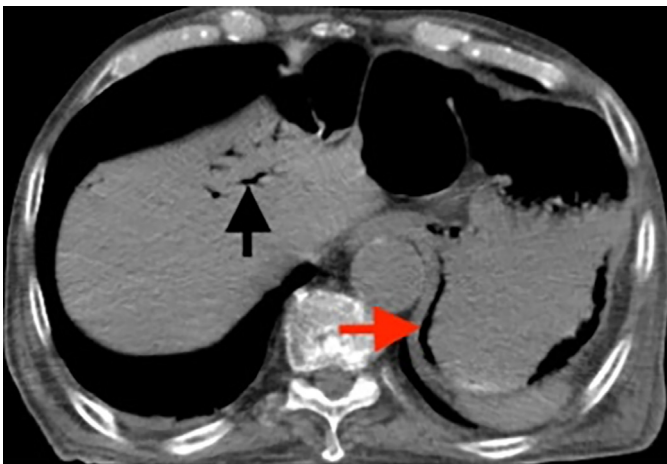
CT image of emphysematous gastritis and air in the portal venous
